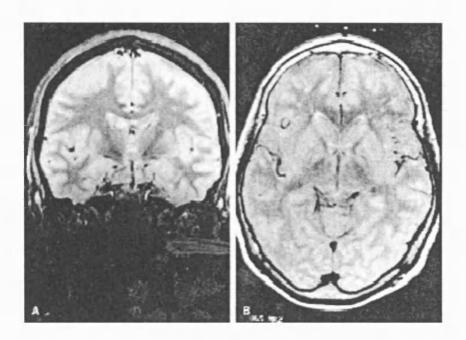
From Hirabayashi et al 2002. Proton density sequence MRI coronal (a) and axial (b) views, showing clear visualisation of pallidal boundary: laterally the putamen, medially the internal capsule and inferiorly on the coronal image the optic tract (dark) is visible. Note the medial medullary lamina separating GPi and GPe is clearly visible.
